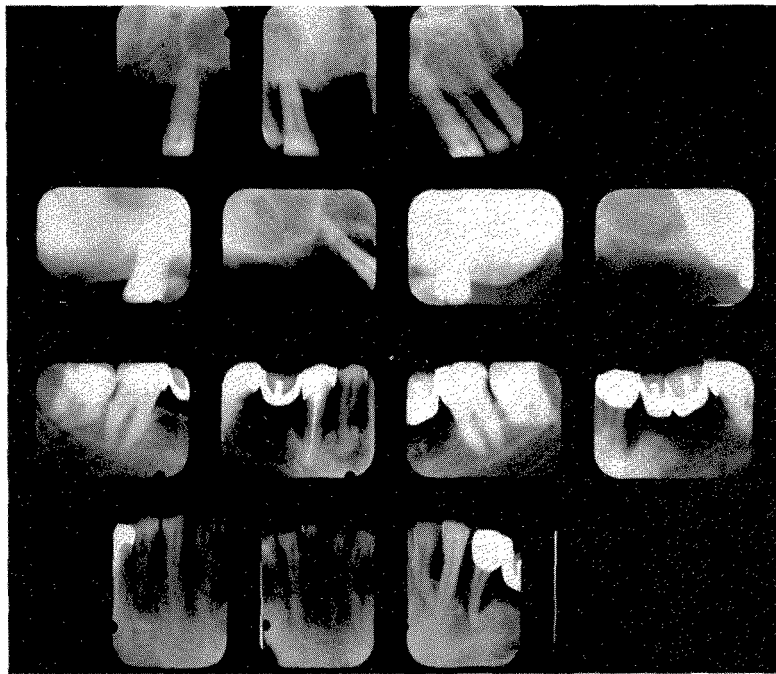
Roentgenograms taken in 1943 just before the removal of the infected teeth and the rehabilitation of the mouth.
